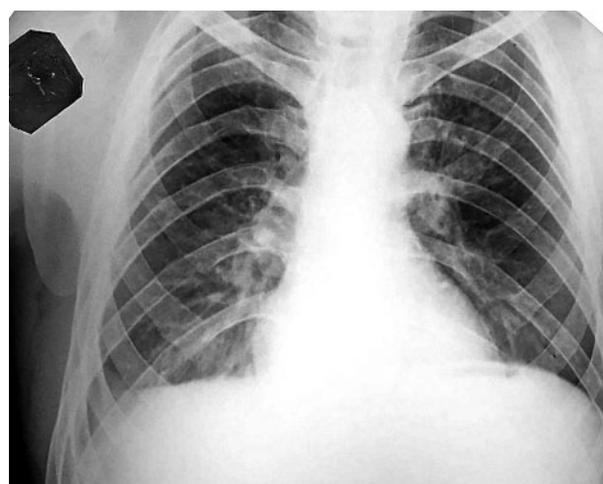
A 35-year old man; chest X-ray at the end of the supportive phase of anti-tuberculosis treatment
